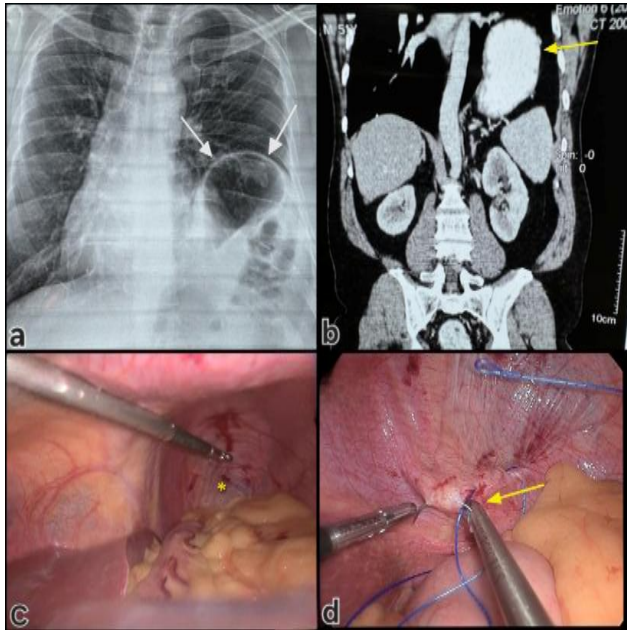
(A-D): (A) Plain X-ray chest PA view showing eventration of left dome of diaphragm (white arrows), (B) CECT chest-abdo showing the same with the contrast filled stomach just under the left dome (yellow arrow), (C) 1st look at laparoscopy showing the ‘deep’ left sided eventration of diaphragm (yellow asterisk), (D) Initiation of plication (yellow arrow).
